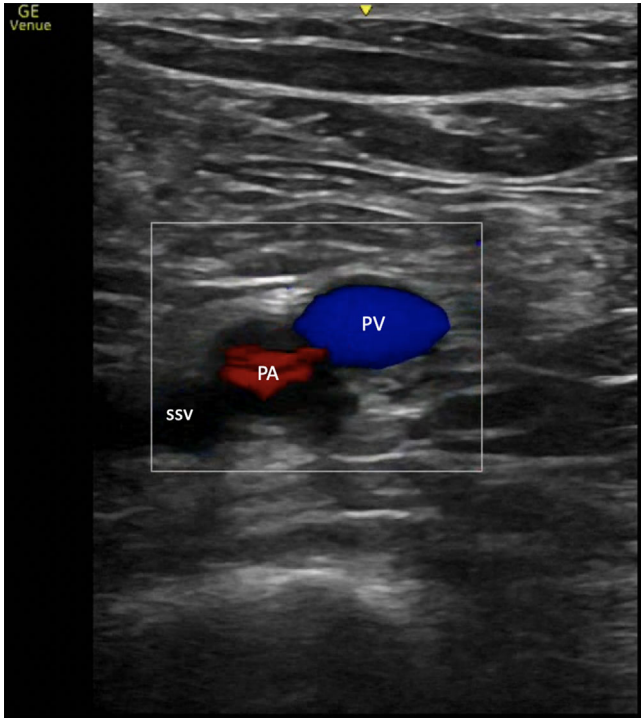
Color Doppler imaging of the popliteal vein demonstrating patency of the vein with augmentation of flow by squeezing the calf. PV, popliteal vein; PA, popliteal artery; ssv, small saphenous vein
